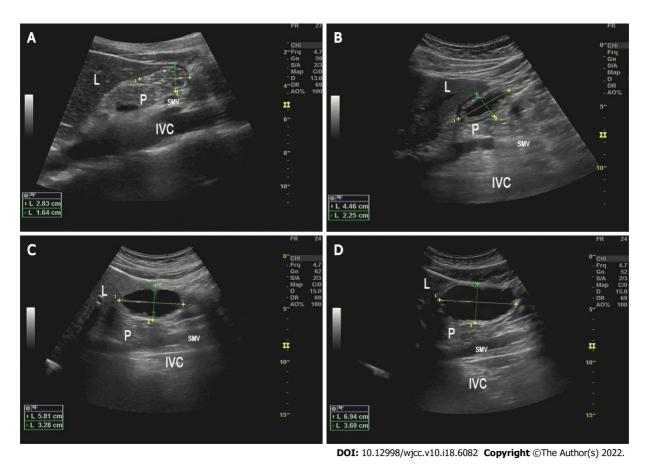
Ultrasonic images of gastric antrum after drinking different volumes of carbohydrates. A: Control group (0 mL); B: Group 1 (100 mL); C: Group 2 (200 mL); D: Group 3 (300 mL). L: Liver; P: Pancreas; SMV: Superior mesenteric vein; IVC: Inferior vena cava.
